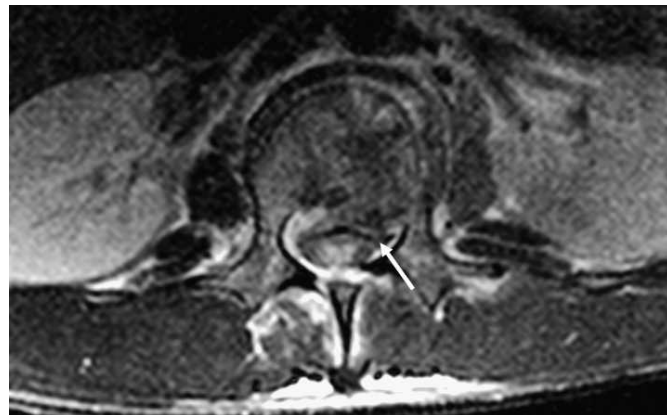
Causes of spinal stenosis and cord compression. Axial T2-weighted image showing a burst fracture with retropulsion of fragments into the canal (arrow).
